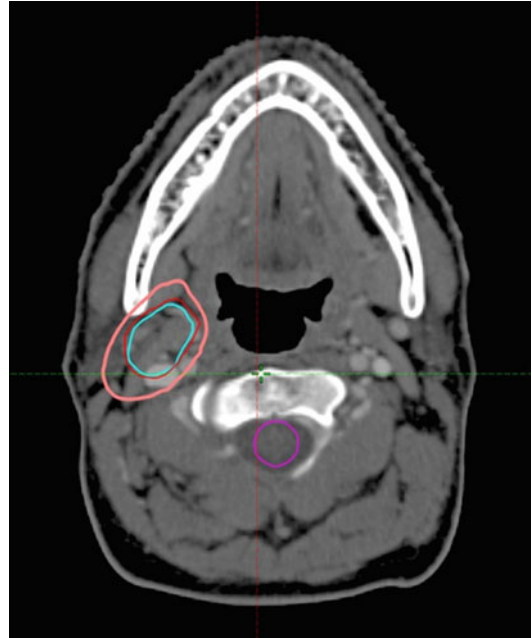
Pre-chemotherapy PET/CT scan. PET+ volume: light blue. GTV: red
